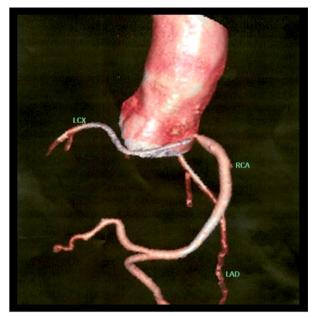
CT Angiogram showing anomalous LCX originating from right sinus with critical ostial stenosis of RCA and LCX.
